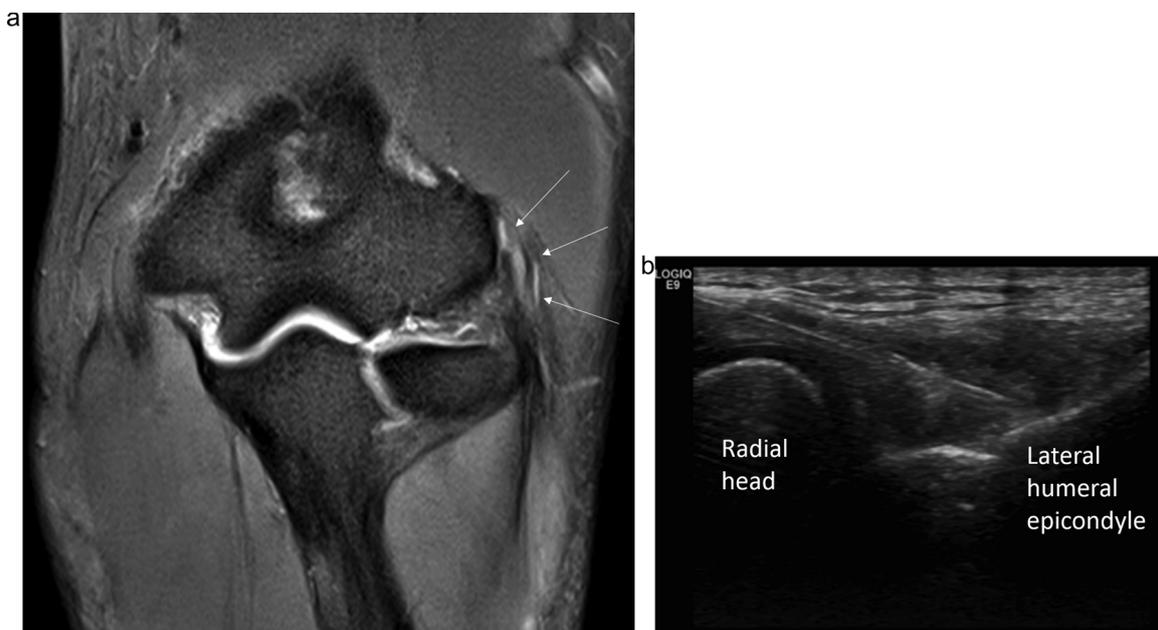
28-year old male golfer with lateral elbow pain. (a) Coronal fat-saturated proton density weighted MRI of the elbow demonstrating inflammation, expansion and delamination of the common extensor origin consistent with tennis elbow. (b) Longitudinal sonogram showing 25 gauge needle in common extensor tendon during PRP injection procedure.
